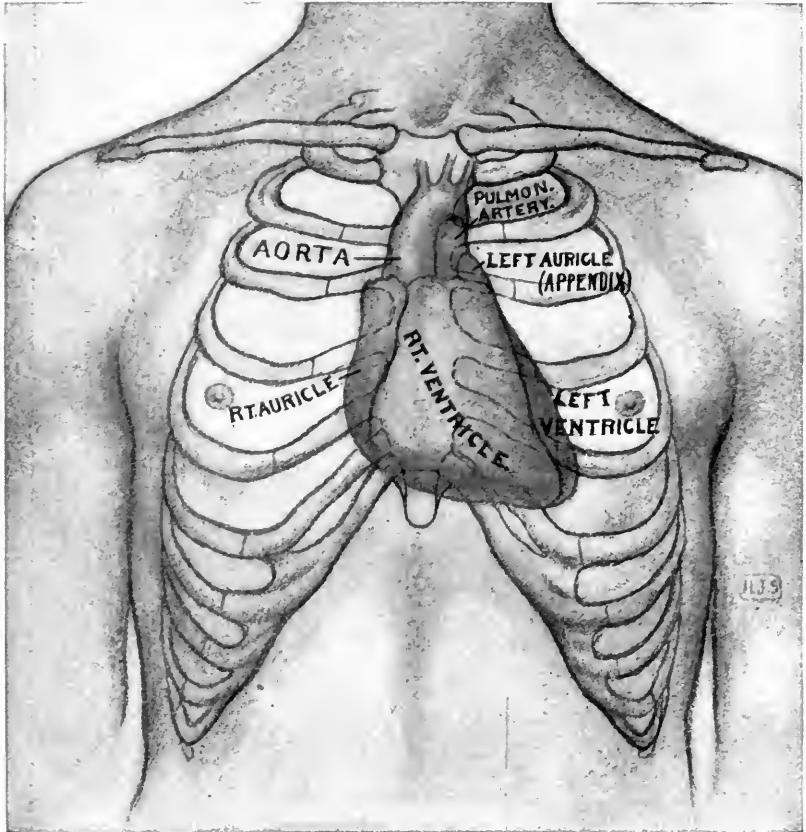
THE ANTERIOR ASPECT OF THE NORMAL HEART AND GREAT VESSELS, SHOWING THEIR RELATIONS TO THE ANATOMIC LANDMARKS (RIBS, STERNUM, CLAVICLES) OF THE FRONT OF THE THORAX. (Butler.)
